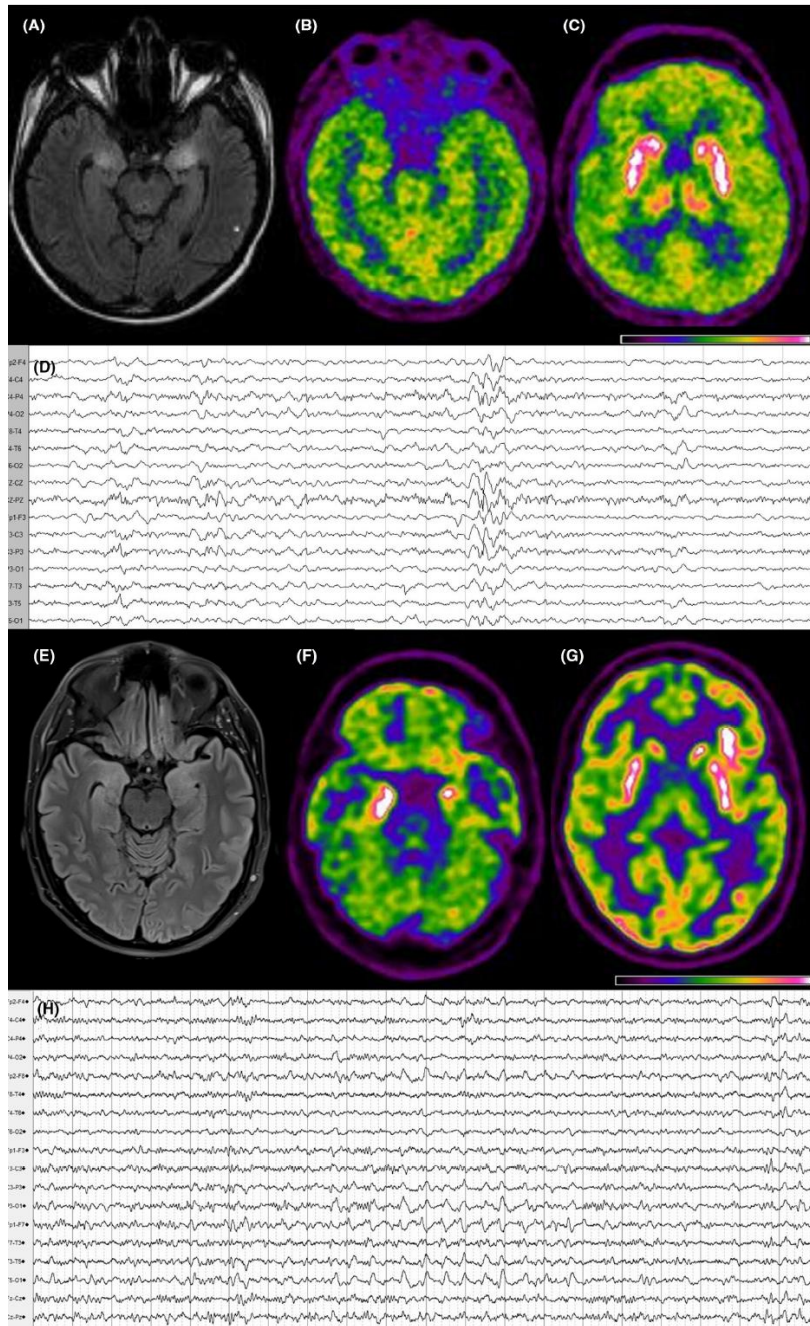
Brain MRI, FDG-PET, and EEG of patient 1 (A–D) and patient 2 (E–H). Only pictures of the most significant abnormalities of MRI, FDG-PET, and EEG are shown. As for patient 1, brain MRI revealed T2/FLAIR hyperintensity in mesial temporal lobe, amygdala, and basal ganglia (A). Brain FDG-PET showed a global hypometabolism along with a relative hypermetabolism of basal ganglia (C). EEG showed slowing of background activity, diffuse sequences of irregular theta-delta waves, and isolated sharp waves and spike-and-waves over central-parietal regions bilaterally (D). As for patient 2, brain MRI showed bilateral T2/FLAIR mesial temporal hyperintensities, more pronounced on the right side, along with enlargement of the amygdalae bilaterally (E). Brain FDG-PET disclosed hypermetabolism in bilateral mesial temporal regions, more evident in the right (F) and left frontal, insular and fronto-temporal regions (G). Inter-ictal EEG showed diffuse slowing of background activity in the left hemisphere, with the occurrence of theta-delta activity and sharp waves over the left temporal regions (H).
